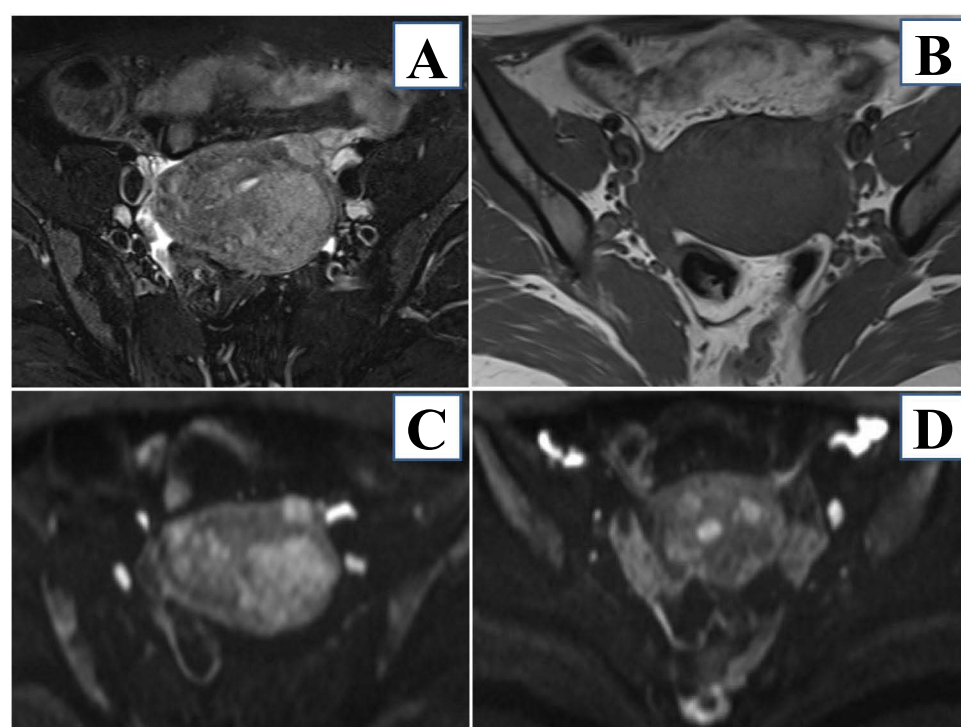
Magnetic resonance images show an ill-margined mass in the uterus, with an intermediate signal on the T2-weighted image (A) and a similar signal on the T1-weighted image (B). Diffusion-weighted image clearly shows a mass of 40 mm in diameter (C) and surrounding nodular lesions (D).
